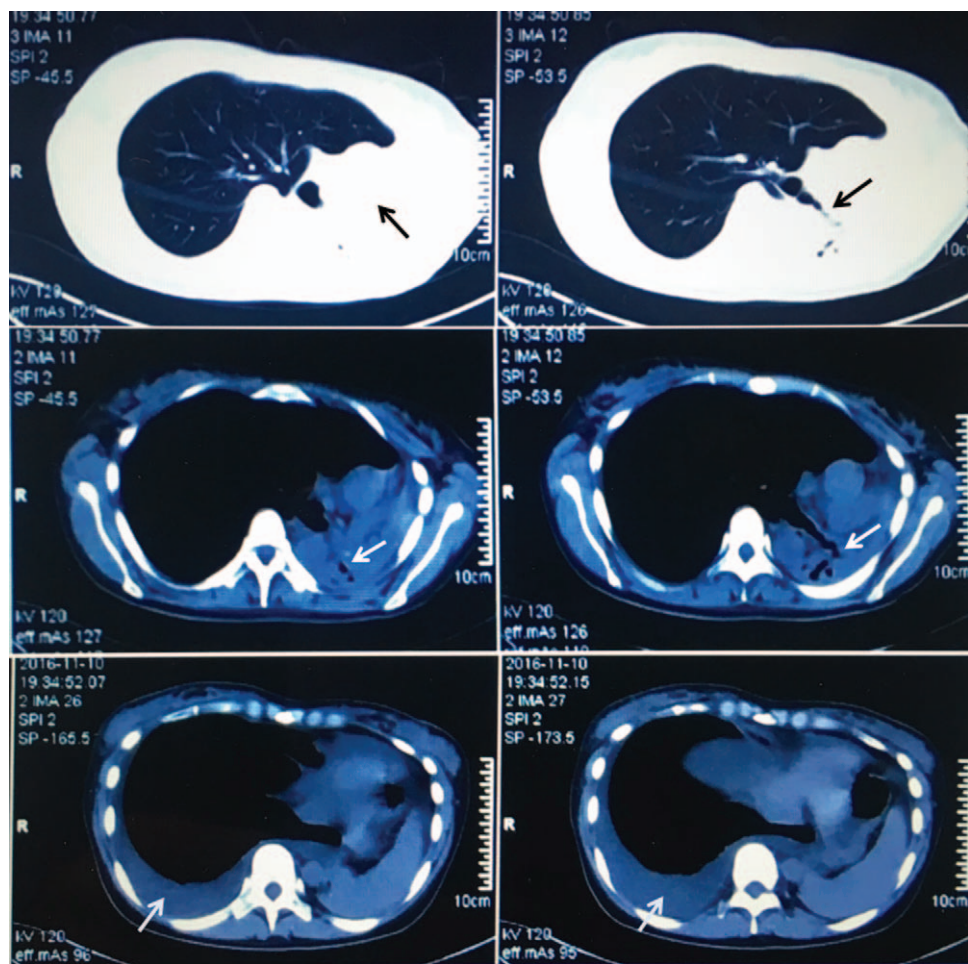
Chest computed tomography. Left main bronchus was cut-off, there was mediastinal displacement to the left side and a right-sided pleural effusion.
